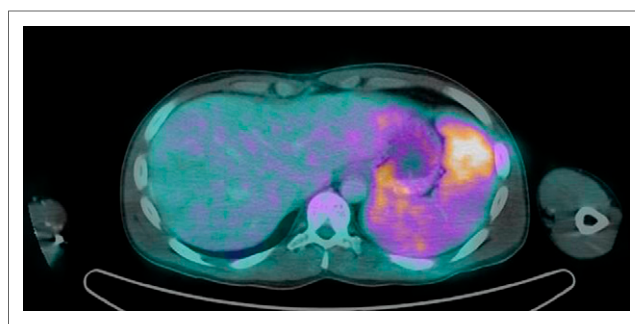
PET/CT image of male patient with spleen embolism.
